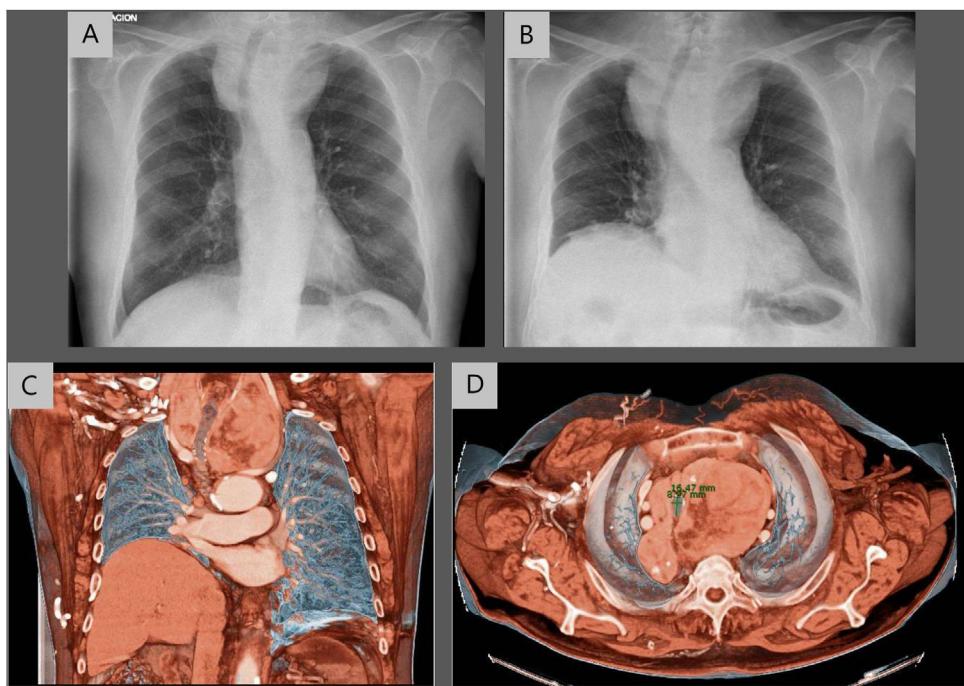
The chest X-ray taken in the Pneumology consultation (B) shows an increase in the widening of the middle mediastinum together with a tracheal deviation and an elevation of the right hemidiaphragm not present in the 2018 image (A). Coronal (C) and axial (D) reconstruction of the chest CT slices shows a large intrathoracic goiter with diaphragmatic elevation, compression of the aorta and decreased tracheal lumen.
